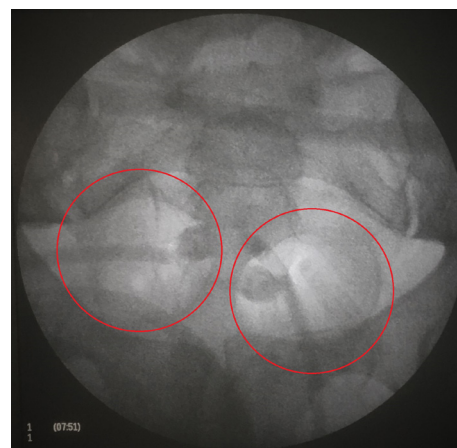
Intraoperative patient's pelvis X-ray scan, unstable pelvic ring damage and development of intrapelvic hemorrhage after stabilization by external fixation devices and deployment of the balloon devices (balloons circled by red)
